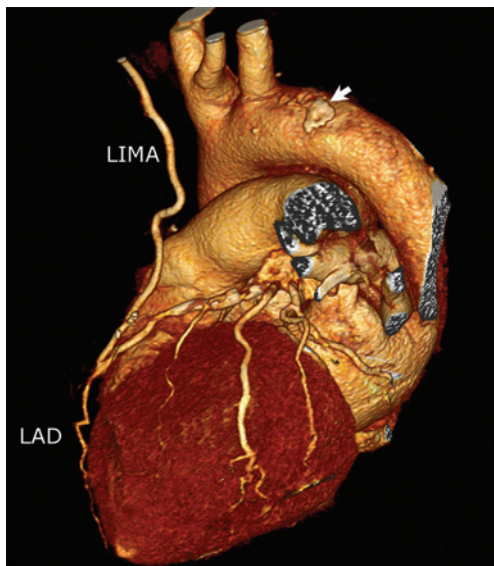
The postoperative computed tomography scan of a patient 1 week after arrested heart total endoscopic coronary artery bypass surgery. The left internal mammary artery (LIMA)/left anterior descending artery (LAD) bypass was found patent. A calcifying plaque at the aortic arch (white arrow) is shown by applying a volume-rendering technique.
